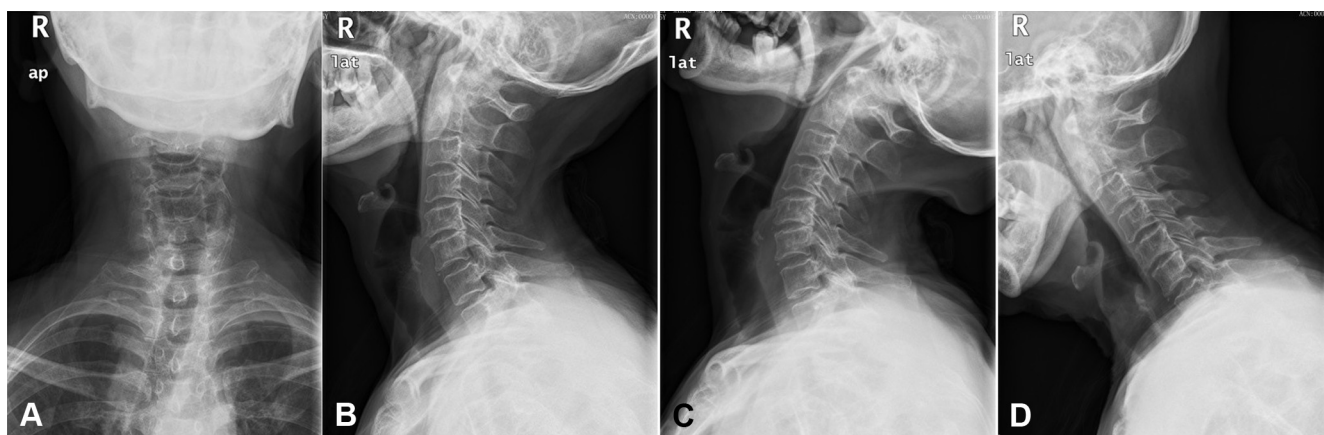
Preoperative cervical (A) AP and (B) lat radiographs demonstrate lytic lesions involving C1 and C2. (C and D) There is no instability on flexion/extension C-spine films. AP, anteroposterior; lat, lateral.
